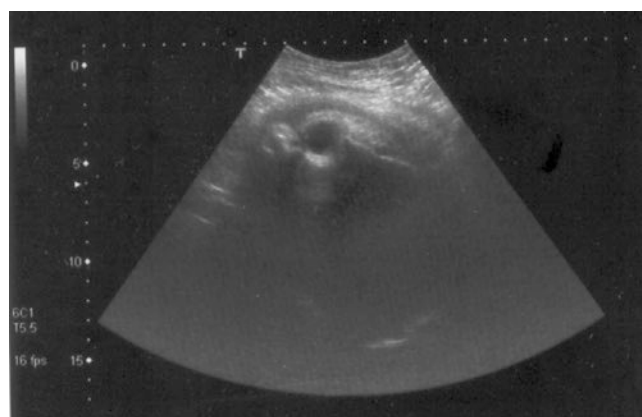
Intrapartum sonography with fetus in left occiput posterior position and posterior asynclitism
